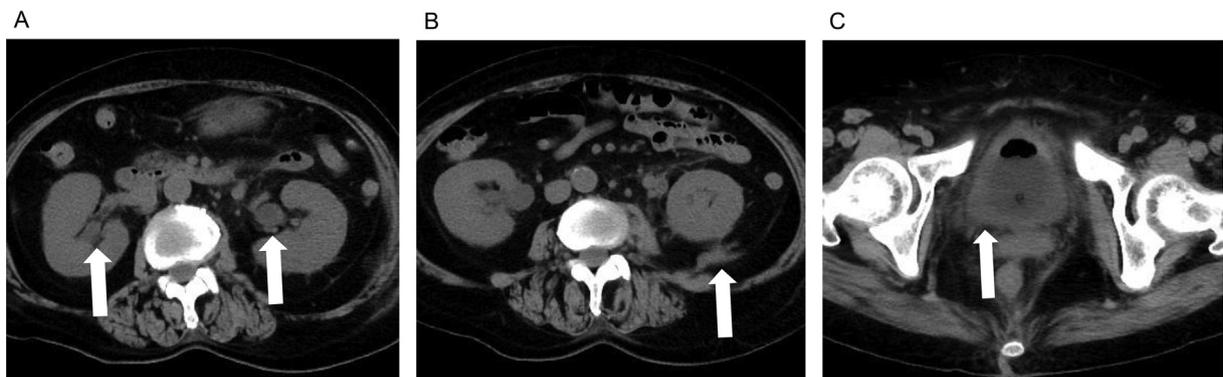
CT scans on day 21 after commencing POM/DEX. A) The arrow shows dilation of bilateral renal pelvises. She was diagnosed with urethritis. B) The arrow shows the spread of inflammation to the left retroperitoneal space. She was diagnosed with peritonitis. C) The arrow shows bladder wall thickening. She was diagnosed with cystitis.
